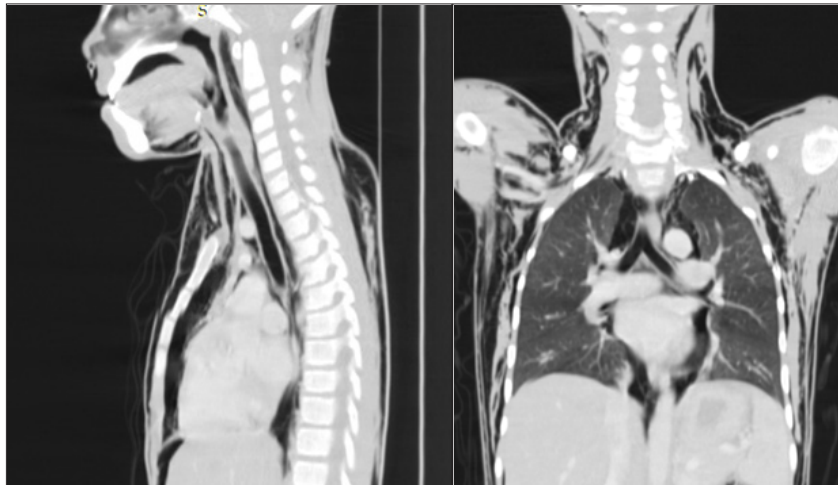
coronal and sagittal sections of chest and neck CT-scan shows air in mediastinum compartment and subcutaneous tissue and grossly normal radio-anatomic image of major tracheobronchial tree and pleural space.
